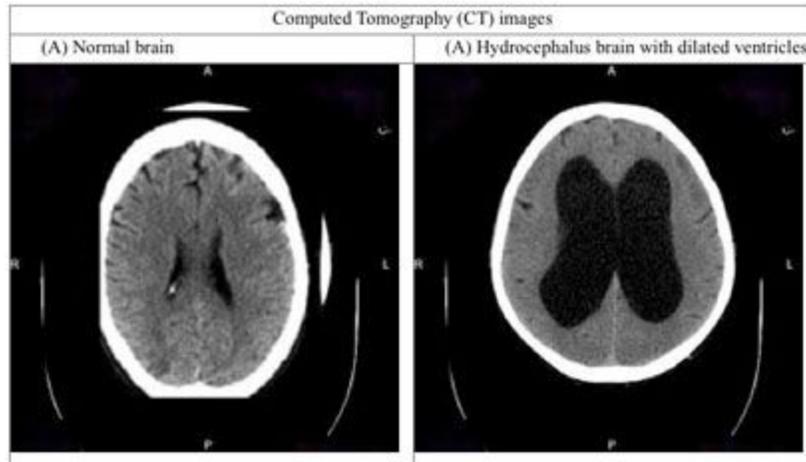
The two CT scans are depicting a normal brain (left) compared to one with hydrocephalus (right). The brain with hydrocephalus has severely dilated lateral ventricles.
